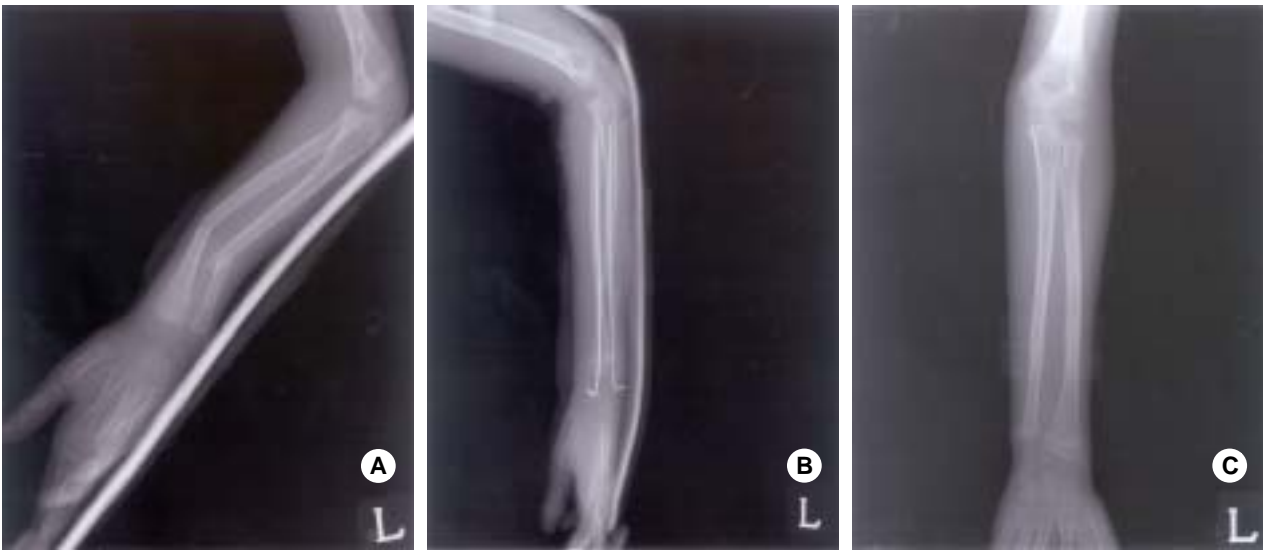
(A) Preoperative radiograph shows angulated and displaced diaphyseal fractures of radius and ulna. (B) Immediate postoperative radiograph of acceptable alignment. (C) Satisfactory union was obtained during follow up.
